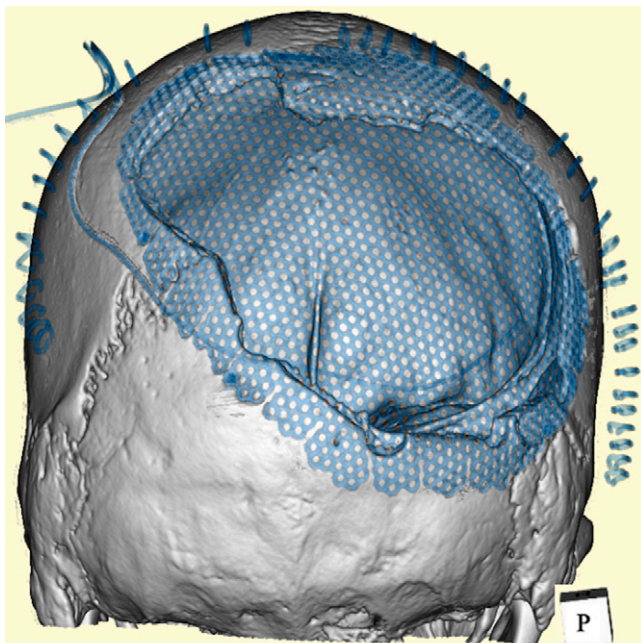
Postsurgical three-dimensional computed tomography revealed total removal of the occipitoparietal lesions with replacement by a titanium flap.
